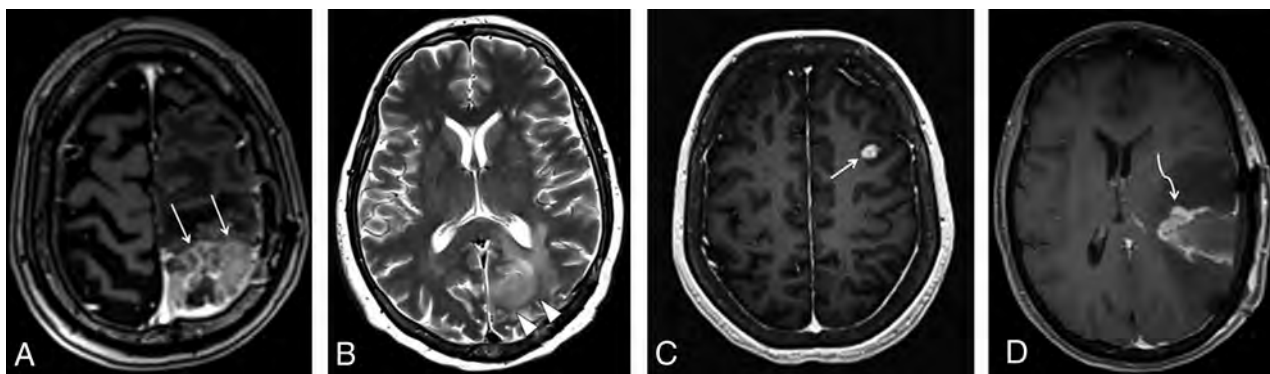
Examples of measurable and nonmeasurable disease, according to the RANO criteria. A, Axial contrast-enhanced T1-weighted image shows a heterogeneously enhancing lesion in the left parietal lobe (arrows), corresponding to recurrent GBM, with both perpendicular measurements of >10 mm, thus representing measurable disease. The more commonly seen examples of nonmeasurable disease are represented in the axial T2 image (B), depicting a hyperintense infiltrating lesion in the left parieto-occipital region (arrowheads) in a patient with anaplastic astrocytoma. The axial contrast-enhanced T1-weighted image (C) shows a subcortical enhancing nodule representing a recurrent GBM (arrow), in which perpendicular diameters are <10 mm. The axial contrast-enhanced T1-weighted image (D) shows residual tumor in the resection cavity of a partially resected GBM (curved arrow), which has poorly defined margins.
